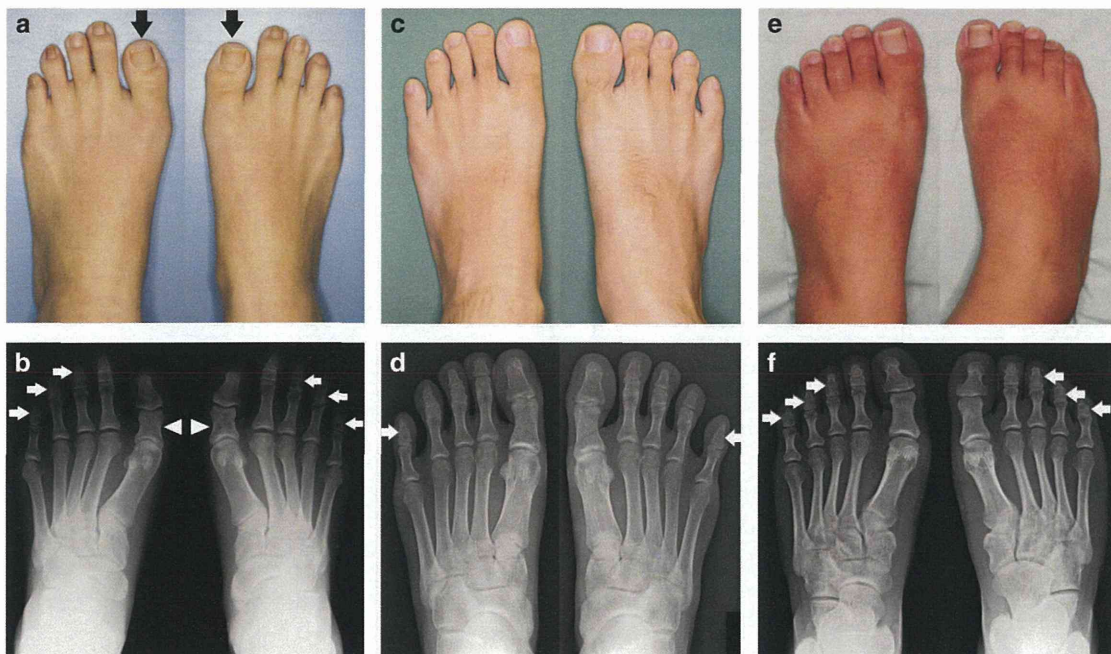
Views and radiographs of the feet of the patients. (a, b) Patient 1, (c, d) patient 2 and (e, f) patient 3. (a, c, e) Views of feet and (b, d, f) radiographs of feet. Black arrows indicate short first toes. White arrows indicate symphalangism. Arrowheads indicate short proximal phalanges (hypoplasia).
